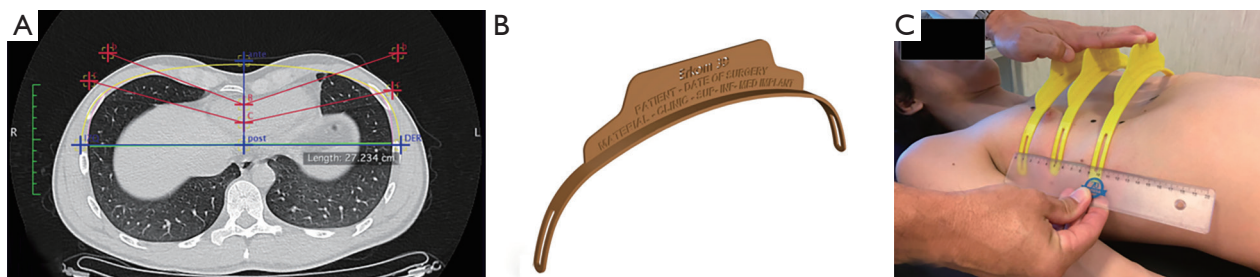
Based on the virtual design of the customized implant using the chest CT of patient in end-expiration phase (A), a virtual template is designed (B), and 3D printed in poly-lactic acid (C). This template will be checked on the patient's chest wall preoperatively. CT, computed tomography; 3D, three-dimensional.
